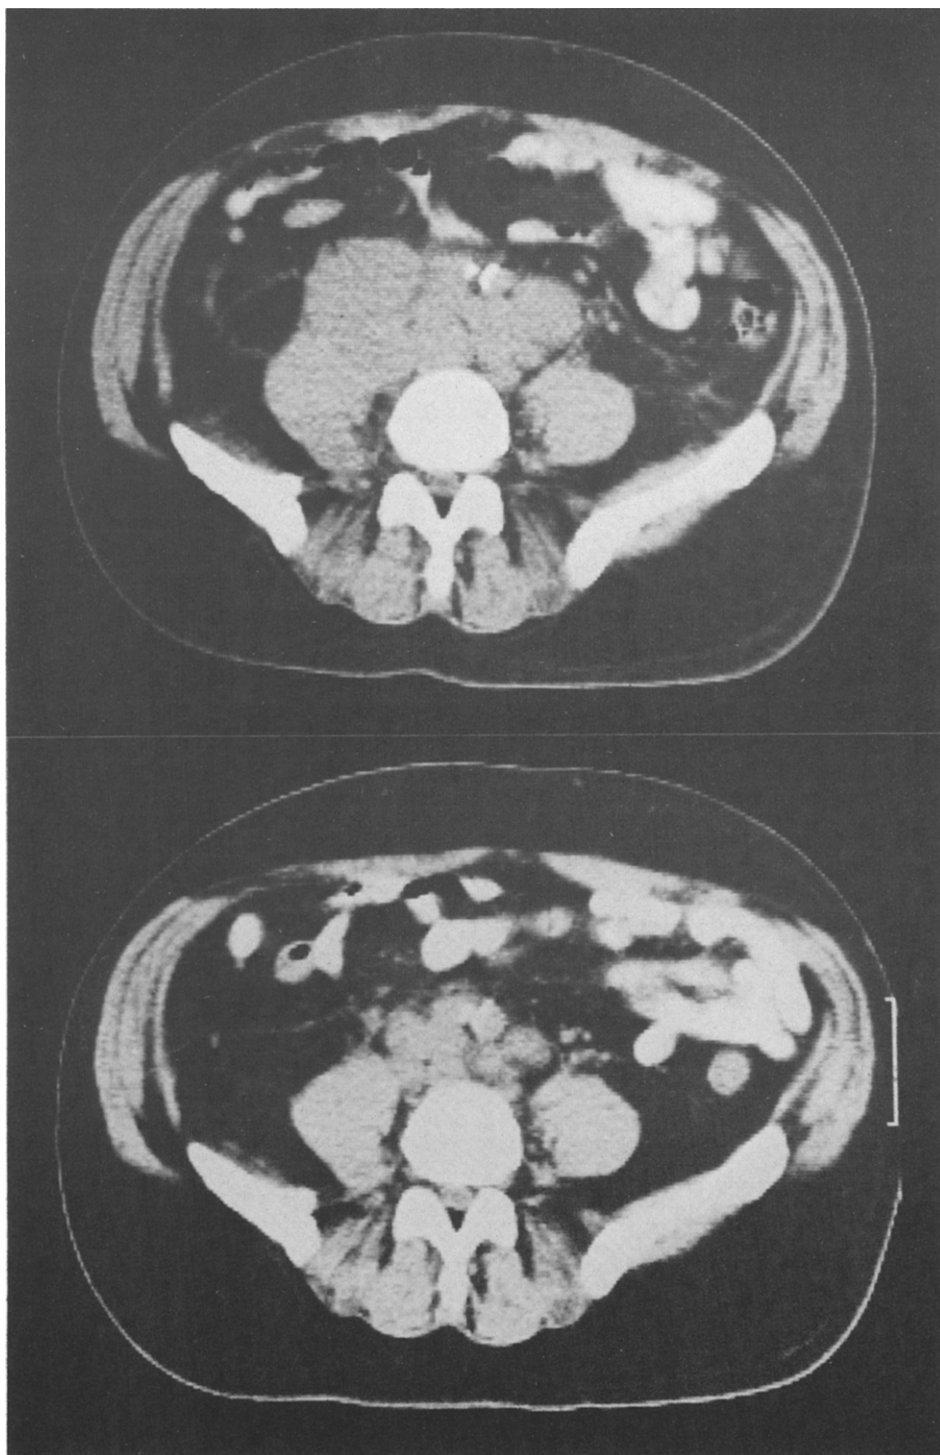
Abdominal CT scan demonstrating a partial response of retroperitoneal lymph node metastases to high-dose ketoconazole in a patient with prostate cancer (patient no. 7).
